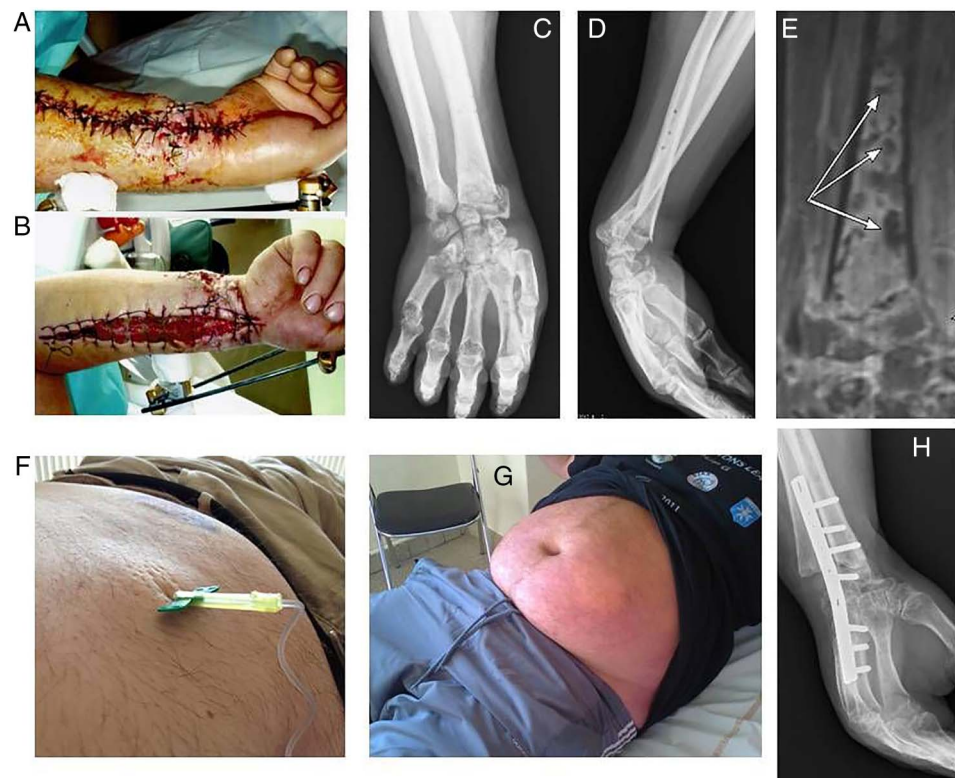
The patient with compartment syndrome following open radial fracture stabilised with external fixation (A). Favourable clinical aspect 1 month after fasciotomy (B). Radial pseudarthrosis (C) with subluxation (D). MRI revealing multiple intramedullary abscesses of the radius (E). Subcutaneous infusion of ertapenem using butterfly disposable needle (F) with tumefaction immediately following the injection in the lower left abdominal quadrant (G). Arthrodesis and favourable outcome (H) after 3 months of antimicrobial therapy.
